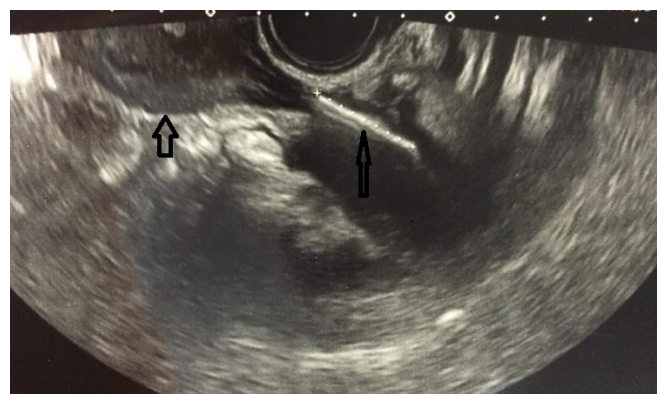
Transvaginal ultrasound in transverse section showing IUCD embedded in the right parametrium.
